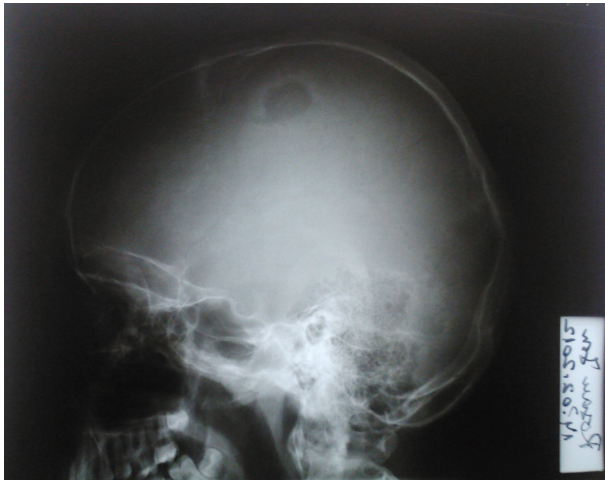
Skull x-ray could identify lack of bone tissue, oval, 3/2 cm, well defined, with a moderate osteosclerotic form located in the right parietal fossa.
